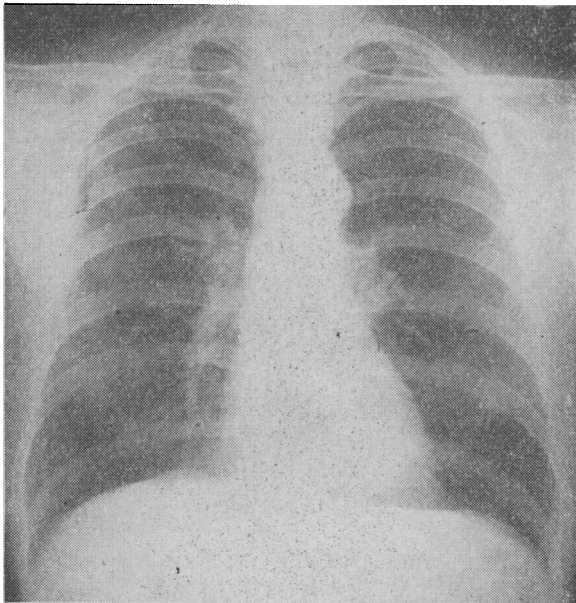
Radiograph taken on 12 February 1963.
